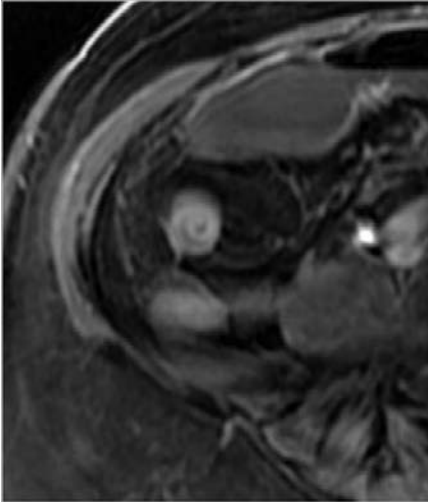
Axial SPGR T1-weighted sequence after i.v. administration of a paramagnetic contrast agent: target sign
